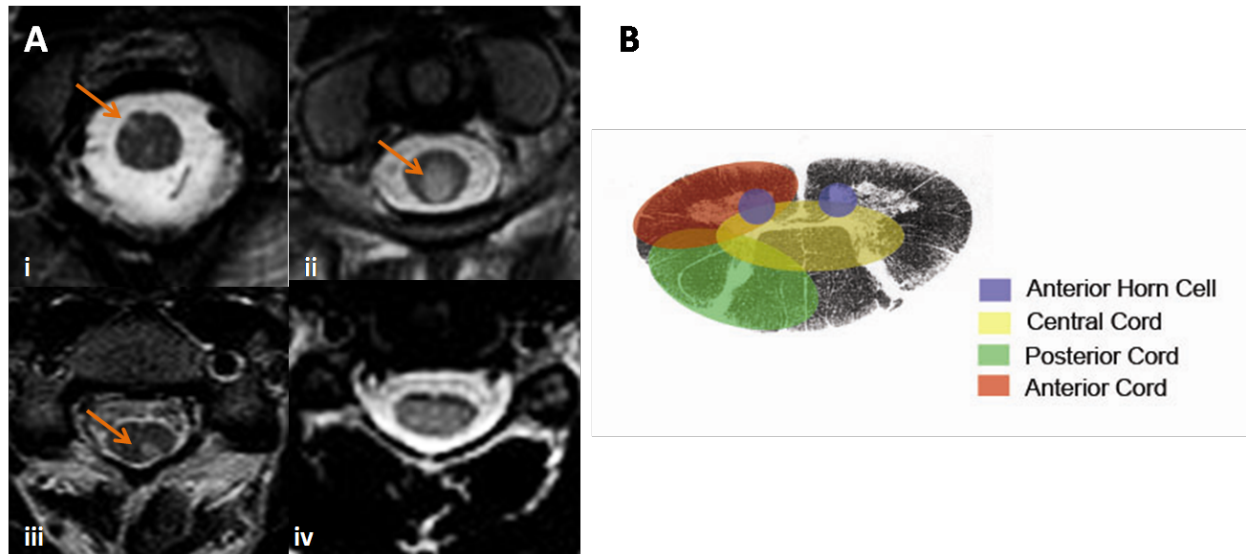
Axial plane anatomical atlas for spine cord lesion scoring. (A) Axial T2-weighted FSE MRI of the spinal cord showing intramedullary regions of hyperintensity: (i) anterior, (ii) centro-posterior, (iii) posterior, and (iv) complete. (B) Cross-sectional atlas of the spinal cord defining intramedullary regions in the transverse plane.
